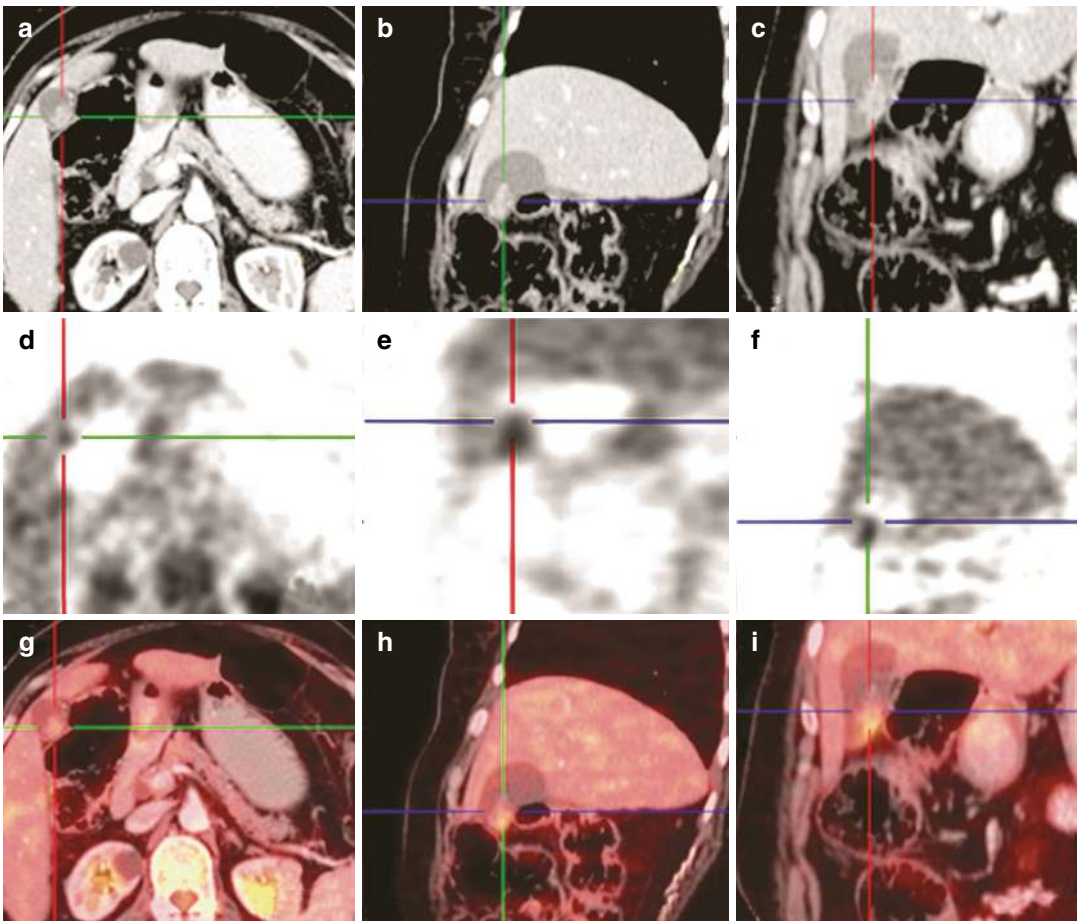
CT images a, b, and c showing a patchily enhancing lesion corresponding to the d, e, and f fused images g, h, and i images for metabolic activity suggestive of the primary lesion
